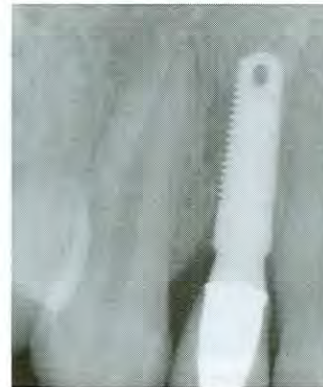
View of the digital radiograph of No. 7 upon completion of the case. Note the contoured emergence profile of the osseous crest, which was sculpted at implant placement and is supporting the interdental soft tissue contours.
